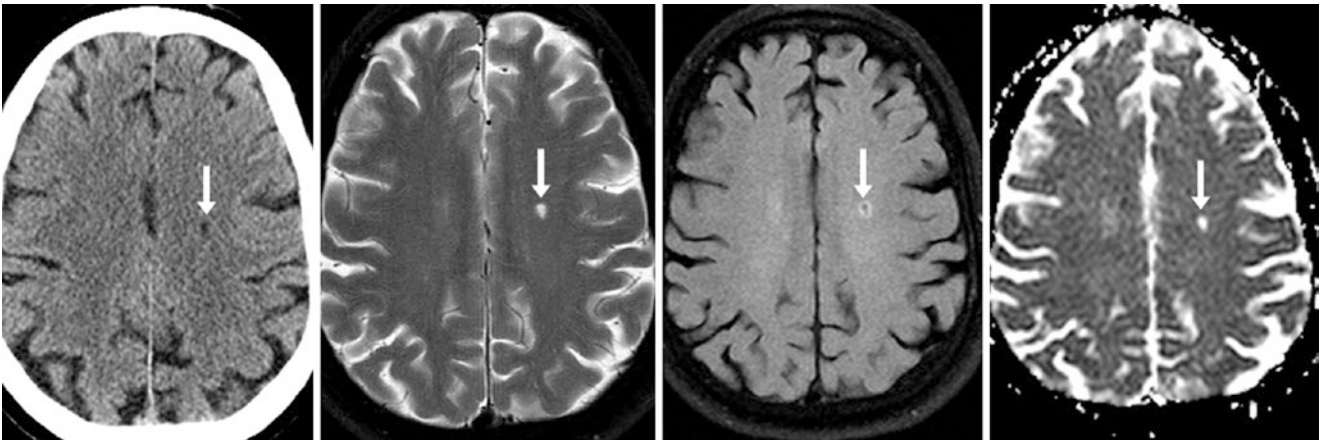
Comparison case of lacunar infarct. A 76 year old had a focal hypodensity (*arrows*) of the centrum semiovale on NECT (*left*) that was hyperintense on T2WI MRI (*left middle*) and only partially suppressed on FLAIR (*right middle*), with high diffusivity on an ADC map (*right*). A dilated PVS of that size should entirely suppress on FLAIR
